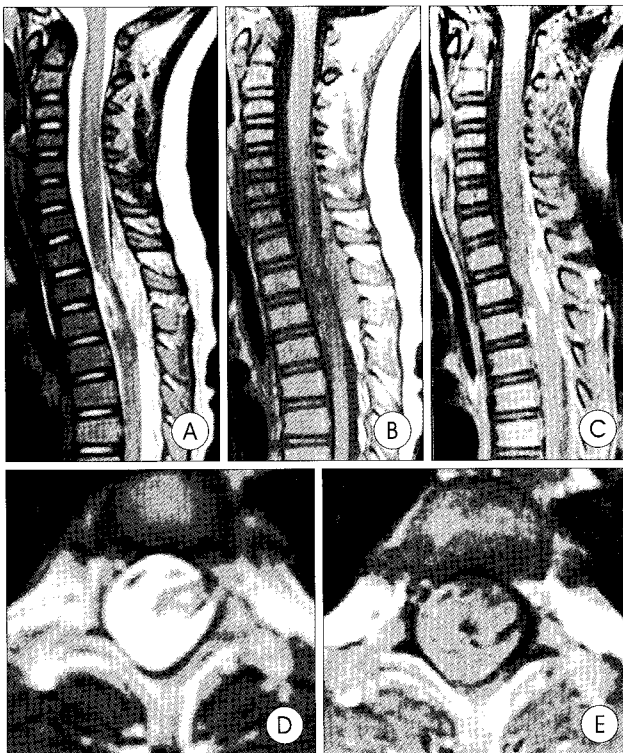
Pre-operative magnetic resonance images of epidural cavernous angioma. A : Sagittal T2-weighted image shows heterogeneous high-signal intensity mass surrounding spinal cord at the level of the C5 through T3. B : Iso-signal intensity on T1-weighted sagittal image. C : Heterogeneous signal intensity on enhanced T1-weighted sagittal image. D : A high-signal intensity mass surrounding spinal cord displaced the cord left laterally on T2-weighted axial image. E : An iso-signal intensity epidural mass on T1-weighted axial image.
